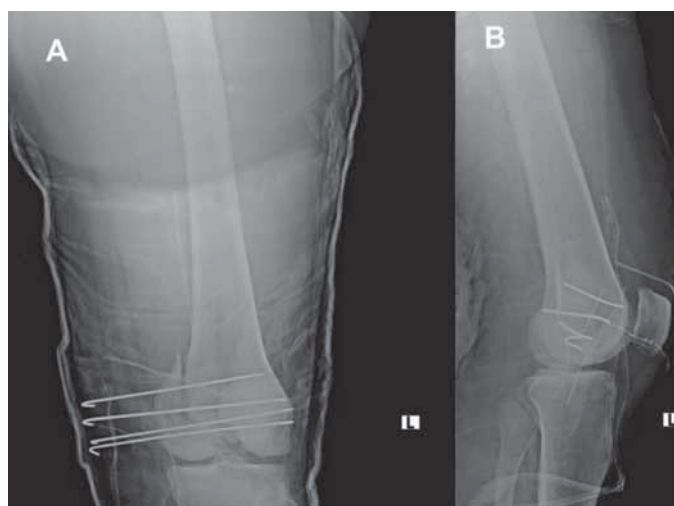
Radiographs of the left knee after temporary fixation of the femoral condylar fragments with 4-K wires: (A) anteroposterior view; (B) lateral view.
